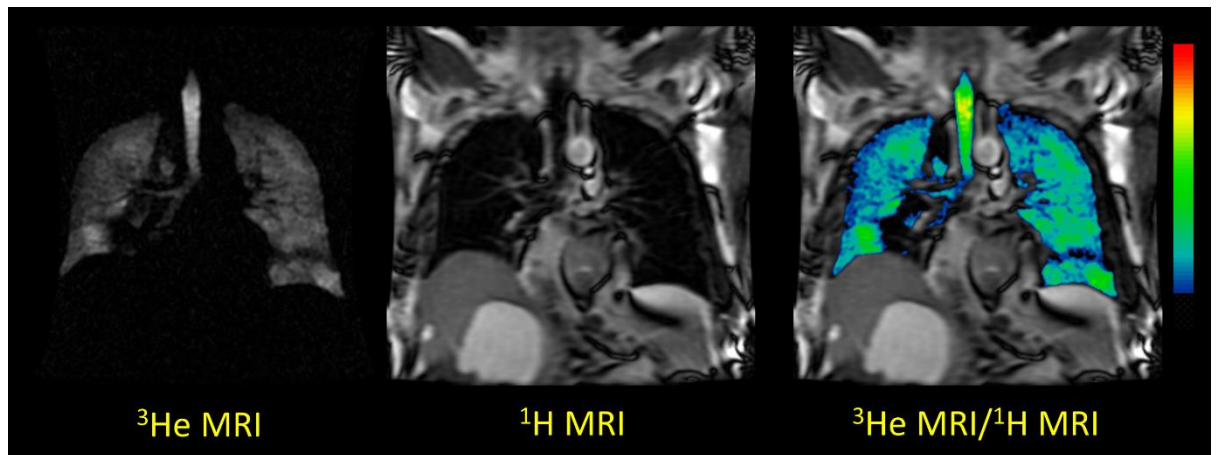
^3He and ^1H MRI acquired during the same breath-hold for patient 2.
